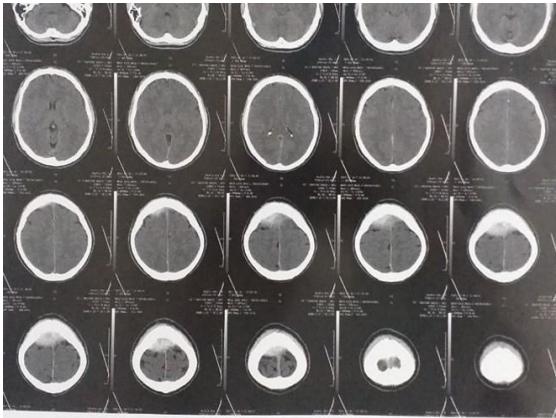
Axial CT brain, soft tissue window, showing VEDH, mainly fronto-parietal
